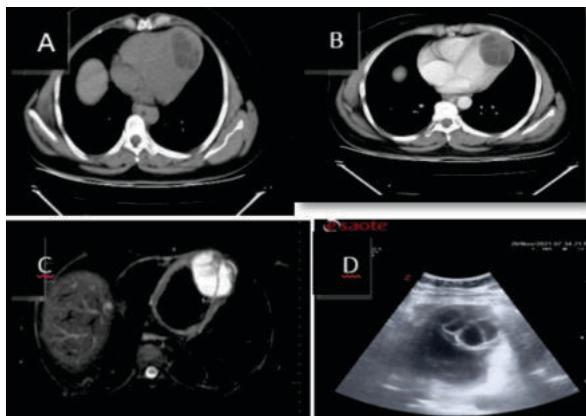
INTRACARDIAC HYDATID showing multiloculated cystic lesion in left ventricle (A) plain (B) contrast enhanced (C) MRI (D) 2d Echo
